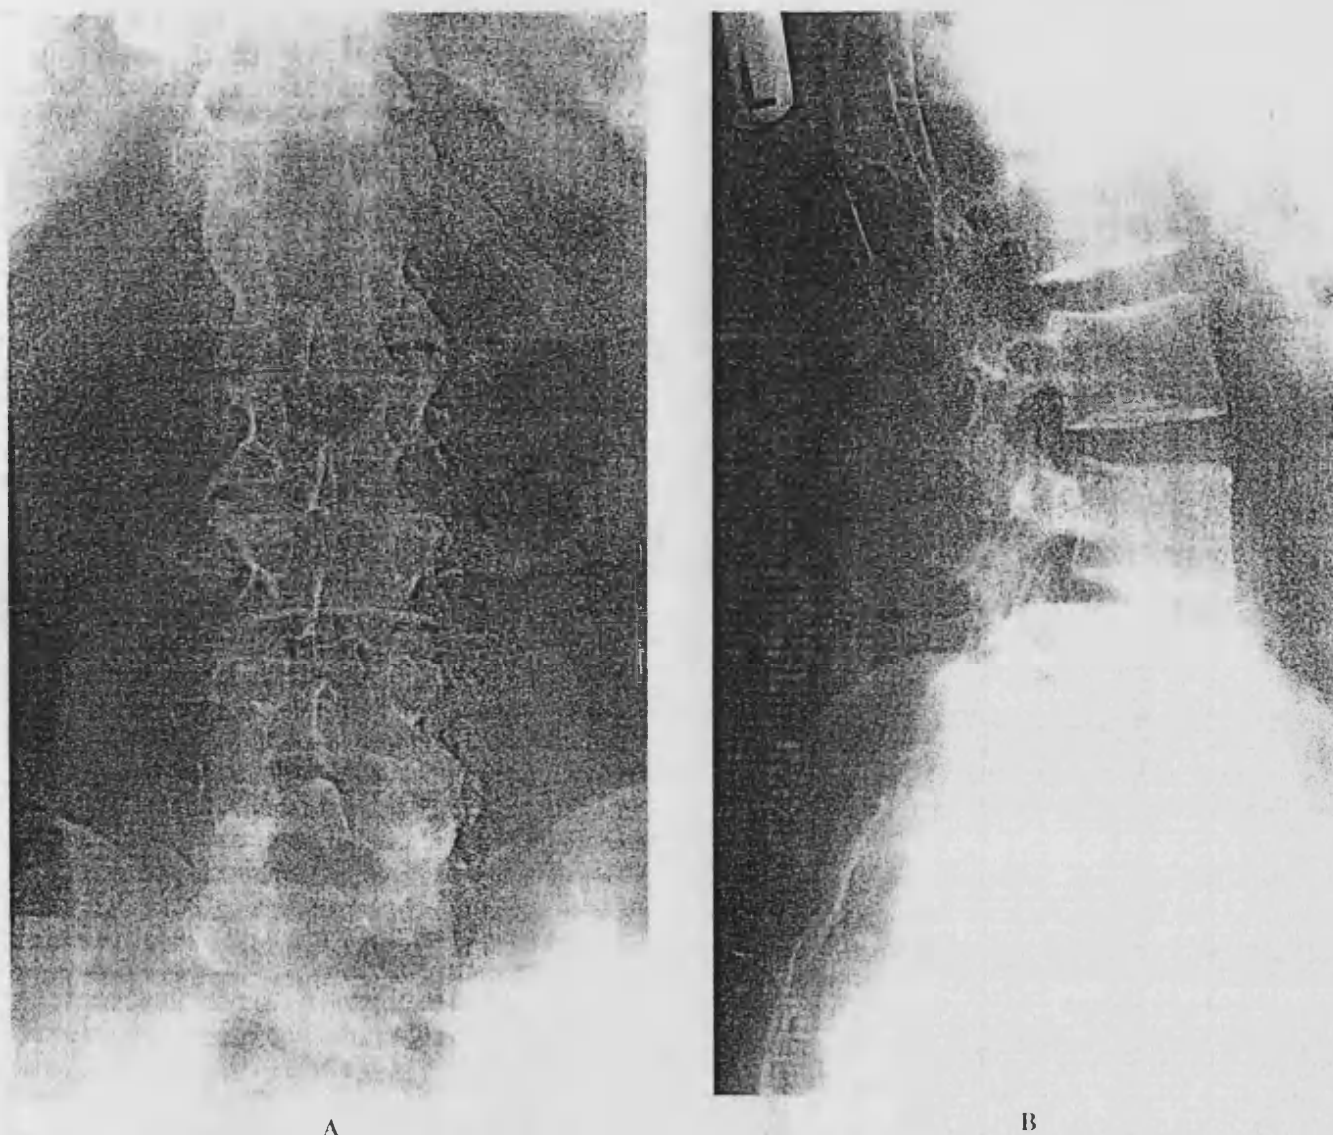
A, Anteroposterior (AP) and B, lateral radiographic views of the lumbar spine of an ankylosing spondylitis patient, obtained on the same day. Syndesmophytes and fusion can be seen in the AP view but not in the lateral view. In a scoring system that uses only the lateral radiograph, the findings on the film in B could be classified as normal.
